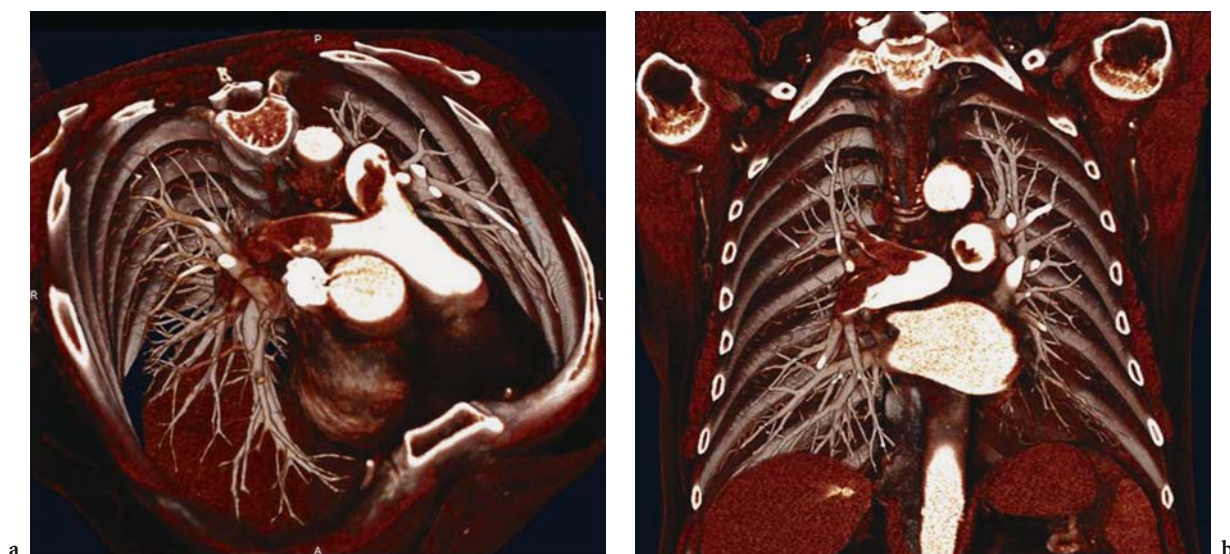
A 72-year-old man with extensive, acute central pulmonary embolism with “saddle embolus” extending into both central pulmonary arteries. Contrast enhanced 16-slice CT examination. Colored volume-rendering technique seen from a frontal cranial (a) and coronal (b) perspective allows intuitive visualization of location and extent of embolism and facilitates communication with referring physicians
